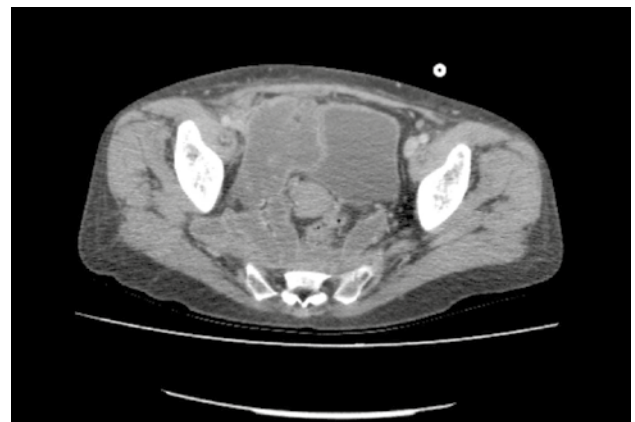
Axial contrast-enhanced CT image demonstrating a fluid collection in the posterior pelvic compartment extending through the greater sciatic foramen.
